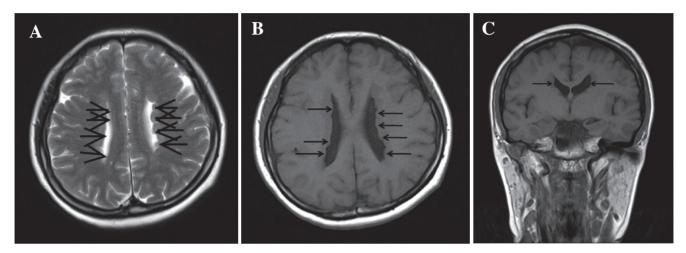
Axial brain MRI demonstrate multiple small nodular heterotopias lining ventricular wall, which are isointense to grey matter in T2 and T1 weighted image (arrows in A, B as well as coronal slice in C)
